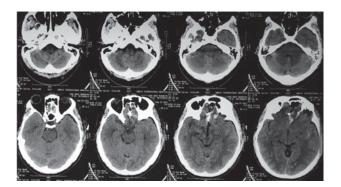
Post Op CT scan of brain showing post operative changes and clip insitu in interhemispheric fissure
